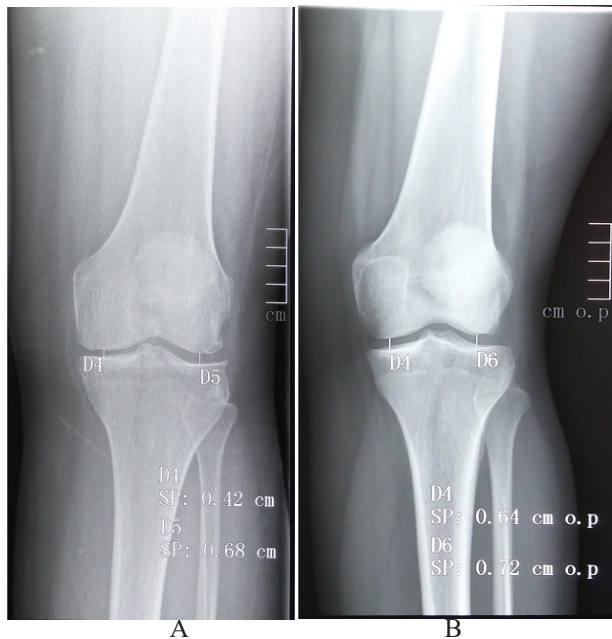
Patient K., 58 years old. Determination of the X-ray joint space asymmetry index in areas of maximum narrowing and expansion: A - before treatment, B - after treatment
